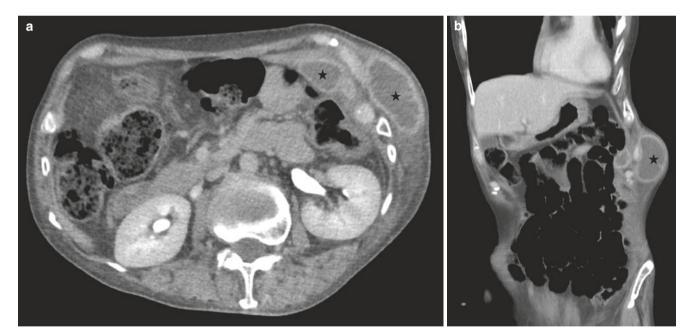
A 70-year-old man presenting with fever and a left lower chest wall lump. (a, b) Axial and coronal CT images show left lower chest wall abscess with deep extension (asterisks)
